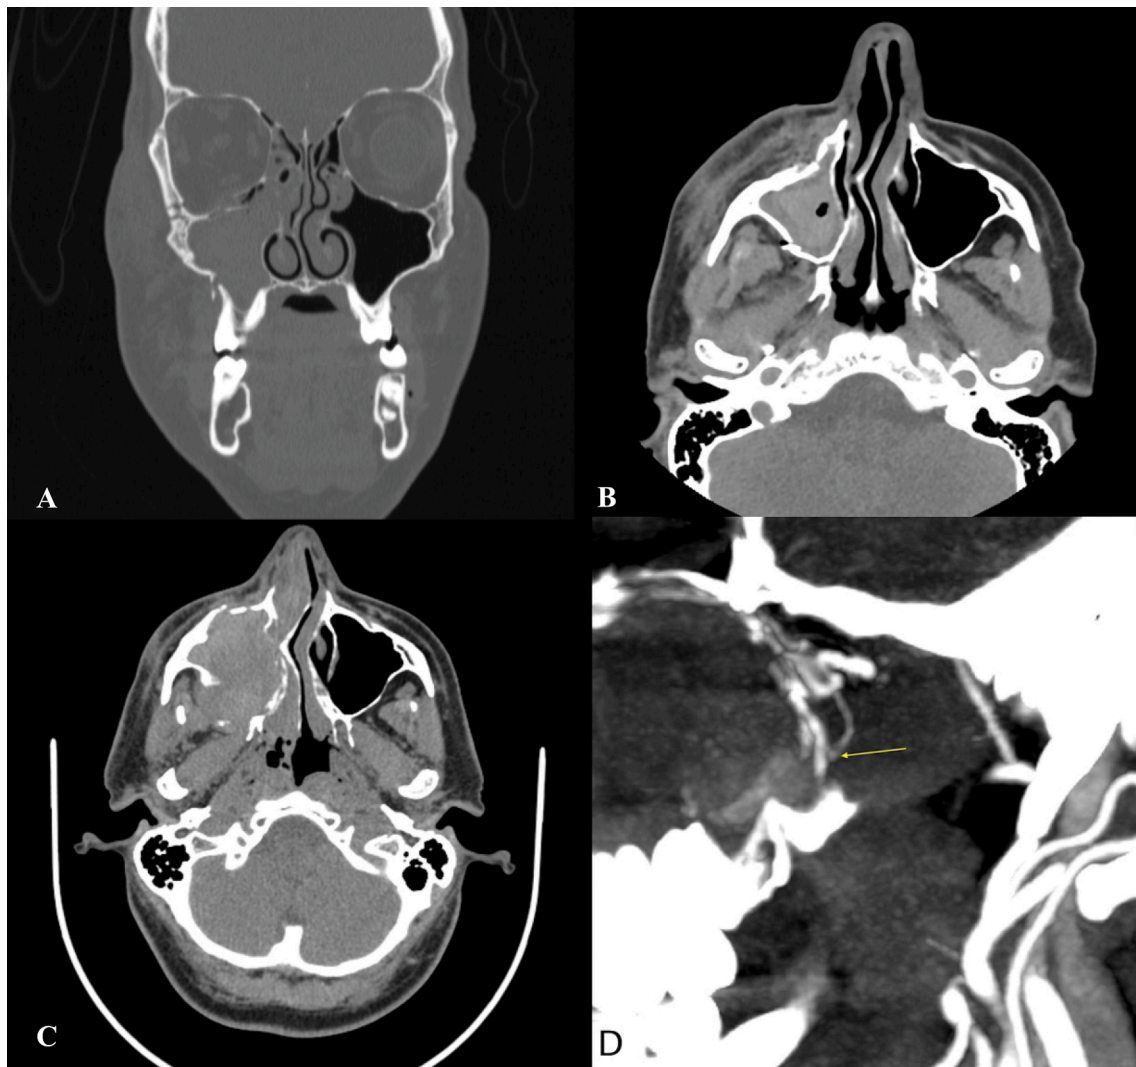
A. Axial Soft tissue window of initial CT showing the fractured walls of the right maxillary sinus with blood in the maxillary sinus. Note that the retroantral fat pad and region of the pterygopalatine fossa is clear; B. Coronal bone window of initial CT showing Zygomaticomaxillary complex fracture on the right with the floor fracture extending through the inferior orbital foramen Axial Soft tissue window of initial CT showing the fractured walls of the right maxillary sinus with blood in the maxillary sinus. Note that the retroantral fat pad and region of the pterygopalatine fossa is clear; C. Axial soft tissue window at the same level as 1B of CT 2.5 months later showing progressive expansion of all walls of the right maxillary sinus notably with posterior encroachment on the retroantral fat and on the lateral aspect of the pterygopalatine fossa; D. Reconstructed oblique image from a follow-up CTA showing a branch from the Internal maxillary forming a pseudoaneurysm encroaching on posterior maxillary sinus.
